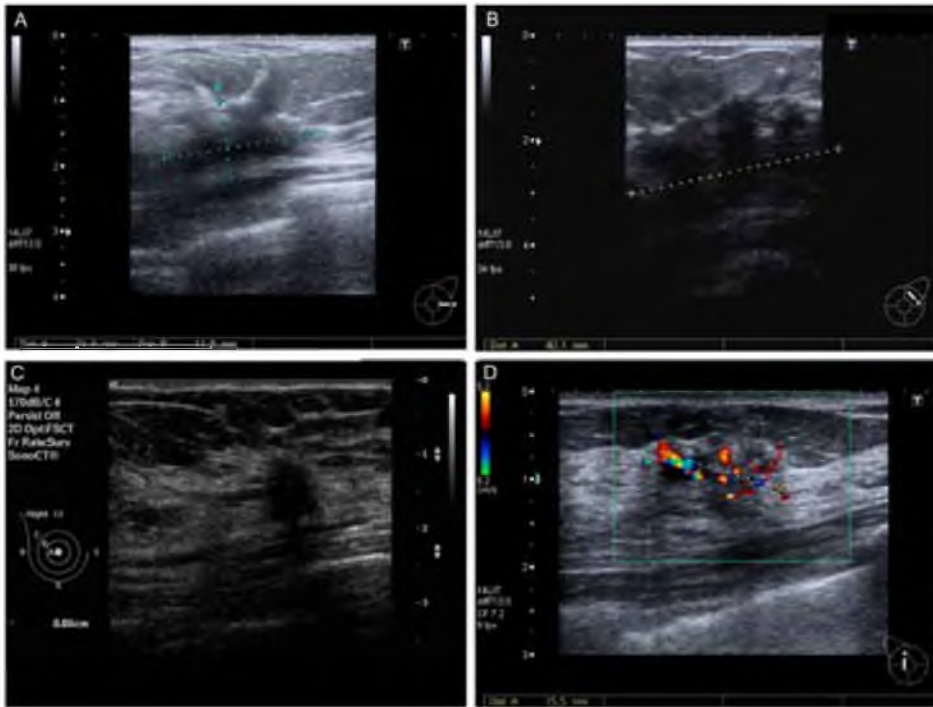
Ultrasound images of 4 different ILC. The tumors in image A, B and C exhibit typical malignant features, showing hypoechoic irregular spiculated lesions with posterior acoustic shadowing. The tumor in image D was almost isoechoic to normal fibroglandular breast tissue but showed multiple pathologic Doppler signals, due to extensive neovascularisation. The tumor in figure A was over 5 cm at pathology, in B over 8 cm, in C 14 mm and in D 3.2 cm, showing that ultrasound measurements especially in larger tumors are far from accurate.
